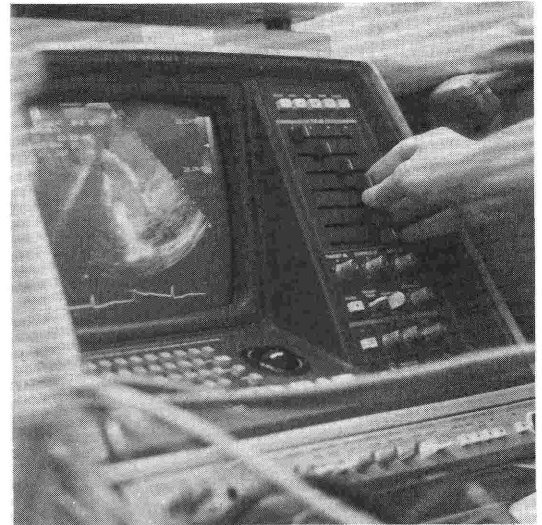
VIII Throughout the bypass operation, a two dimensional transesophageal echocardiogram shows the status of the heart.
